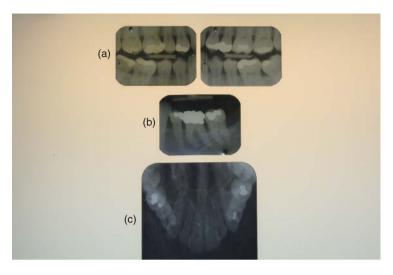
Examples of intra-oral radiographic views. (a) Bitewings. (b) Periapical. (c) Upper occlusal
